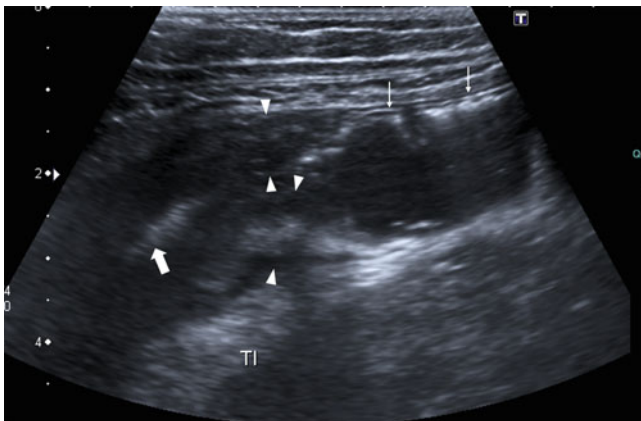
Inflammatory stricture of the terminal ileum, in a patient with Crohn's disease. High resolution ultrasound along the length of the terminal ileum shows fluid distended normal terminal ileum (white arrows), with an acute transition to markedly thick-walled distal terminal ileum (arrow heads outline anterior and posterior walls), with a little gas in the almost effaced lumen (fat arrow)
